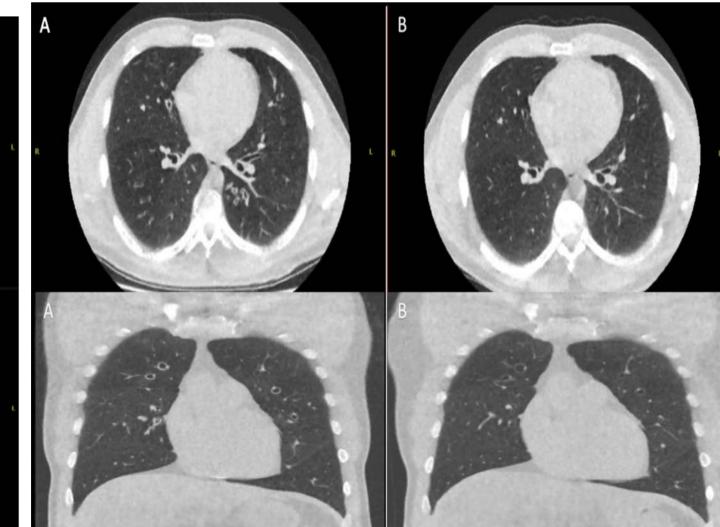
(Patient 1) Ultra-Low Dose CT Thorax pretreatment (A) and 24 weeks post modified dose regimen(B)
